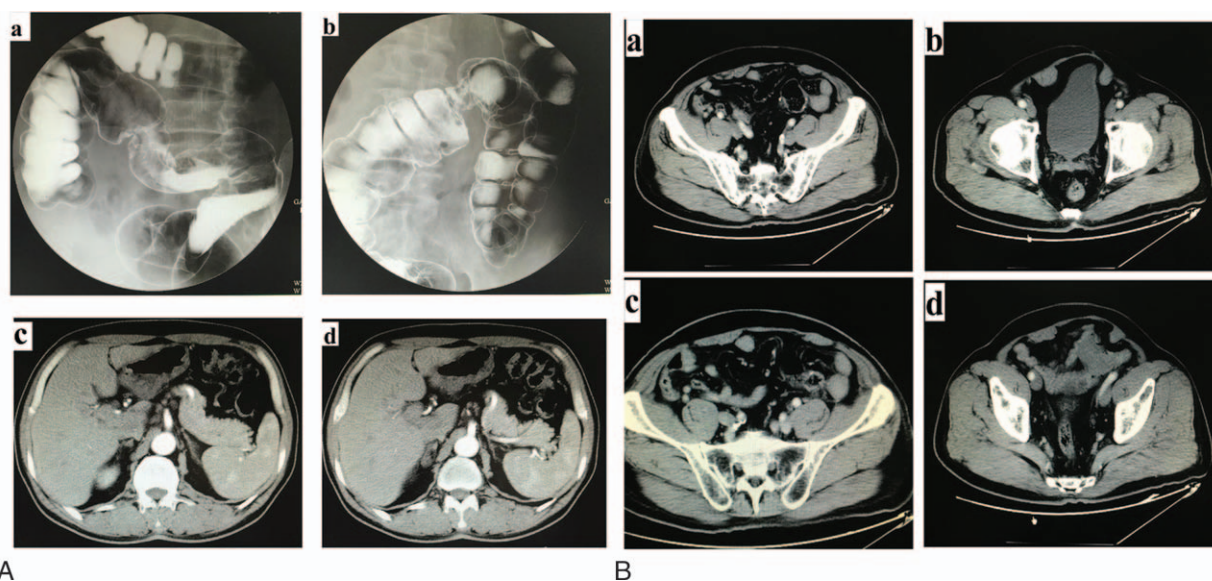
A, Double air-barium contrast examination revealed a narrow lumen with irregular contours, intestinal wall rigidity, and thickened mucosal folds (a–b). The abdomen CT scan revealed bowel wall thickening suggesting tumor invasion (c–d). B, The abdomen CT scan at the time of colon resection revealed an incisional hernia (a–d).
